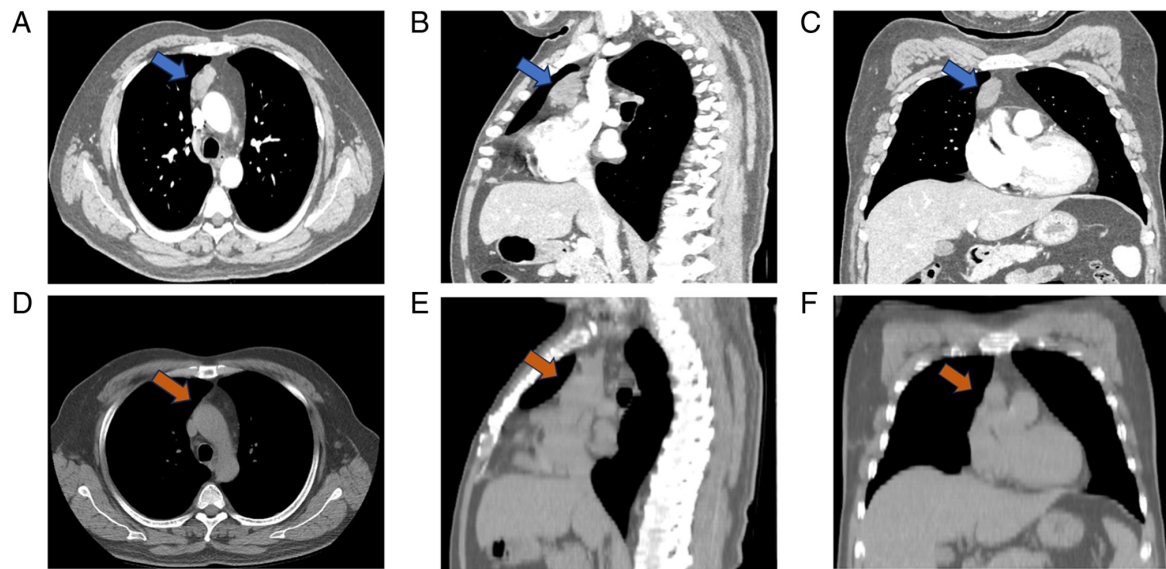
Pre-operative and post-operative radiological assessment of the anterior mediastinal tumor. (A-C) Pre-operative contrast-enhanced chest CT scans (mediastinal window). (A) Axial view; (B) sagittal view; and (C) coronal view. The blue arrows indicate a well-circumscribed, lobulated soft-tissue mass located in the anterior mediastinum. Note the clear interface between the tumor and the surrounding mediastinal fat and great vessels, suggestive of a non-invasive lesion. (D-F) Post-operative chest CT images after tumor resection. (D) Axial view; (E) sagittal view; and (F) coronal view. The images confirm the complete resection of the lesion with no evidence of local recurrence.
